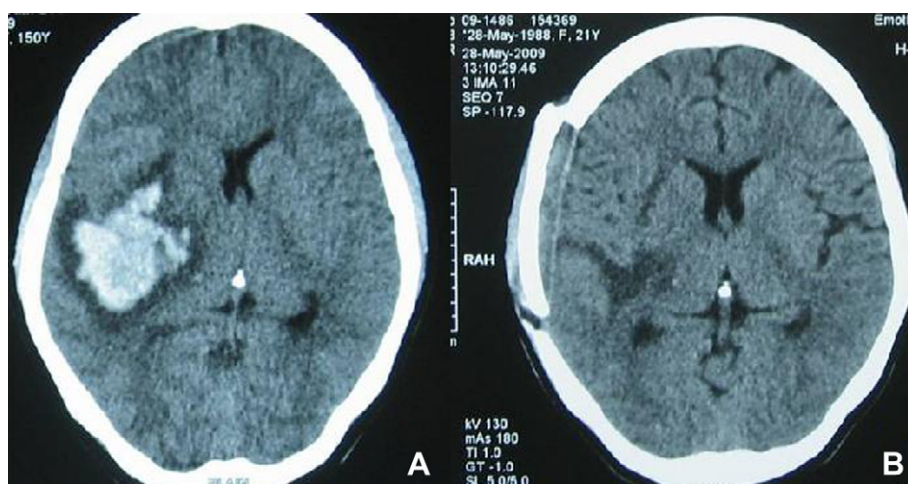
A non-contrast computed tomography scan of the head A) Pre-operative image showing intracerebral hematoma measuring $5.5 \times 4.8 \times 4.2$ cm involving the right ganglio-capsular region with midline shift of 7–8 mm towards left. B) Post-operative image showing complete evacuation of the hematoma.
